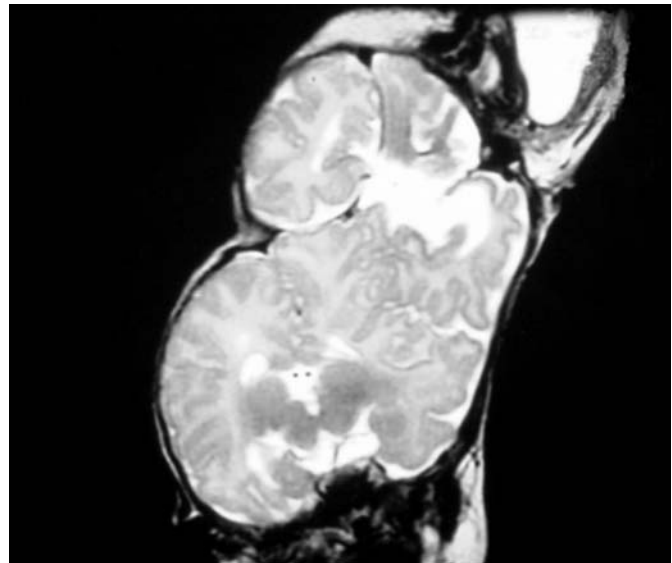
Coronal T2-weighted magnetic resonance imaging sequence showing that the left cerebral hemisphere of the autosite is confluent with the right cerebral hemisphere of the parasite.
